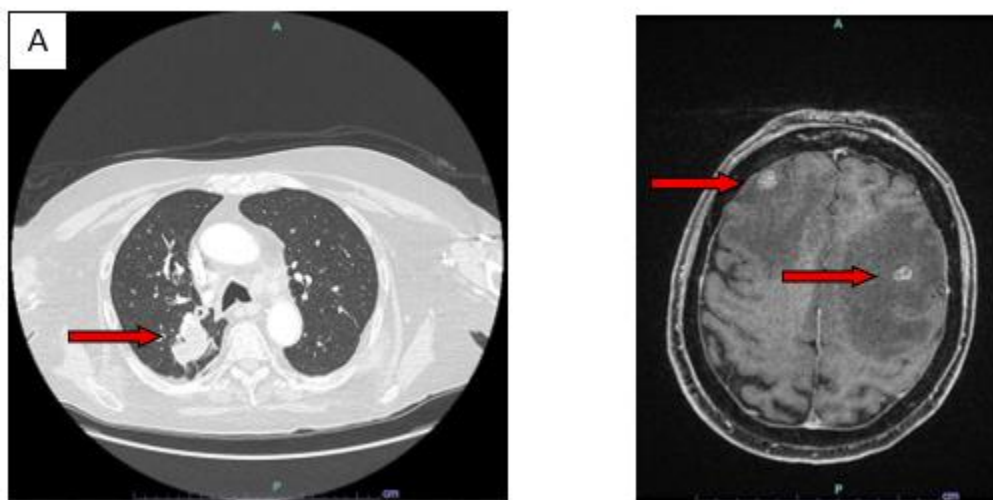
Chest (A) and brain (B) computed tomography (CT) images on January 2024. The chest CT shows a lesion close to the right costal pleura (40 x 43 x 43 mm) and multiple mediastinal lymphadenopathies. The brain CT shows two focal lesions on the right and left frontal brain lobes with perilesional edema.
